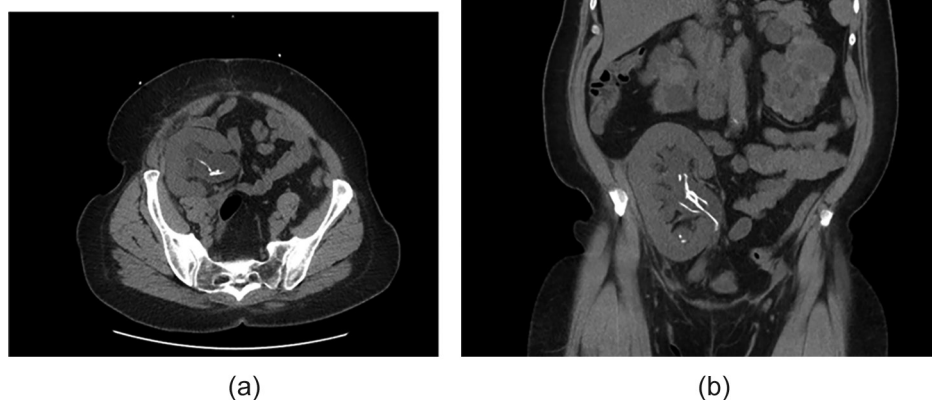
Non-contrast CT showing atypical renal calcification seen in renal pelvis of transplanted kidney due to retained nephrostomy thread. A, Axial view. B, Coronal view.
